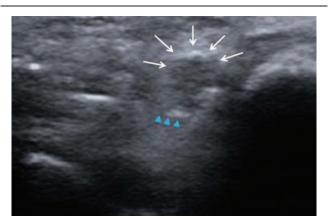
Transverse ultrasound image of the right ulnar nerve. The white arrow indicates the right ulnar nerve, and the blue arrowheads indicate the catheter needle.
